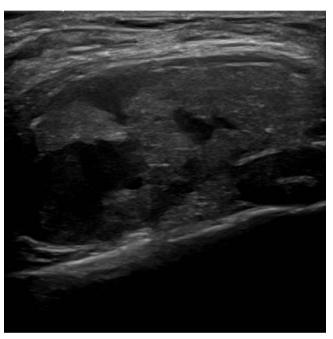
On ultrasound performed in an outside clinic, a large heterogeneous hypoechoic mass with echogenic rim is seen in the right chest wall under pectoralis major muscle.
